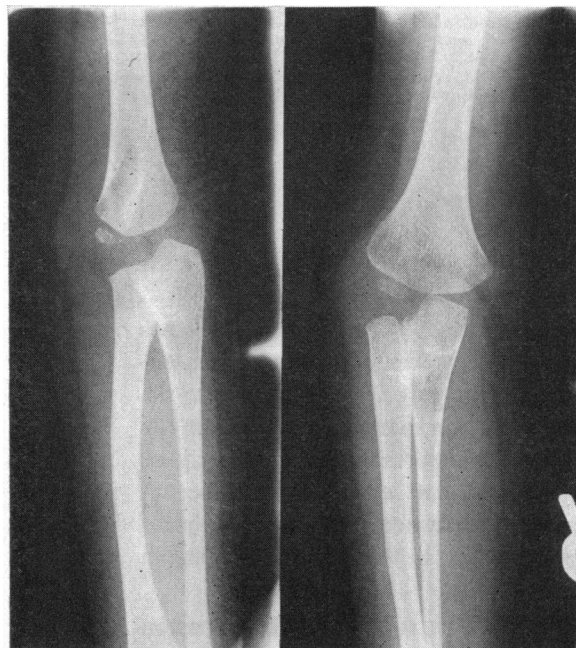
X-ray film of elbows showing radial-ulnar synostosis.
